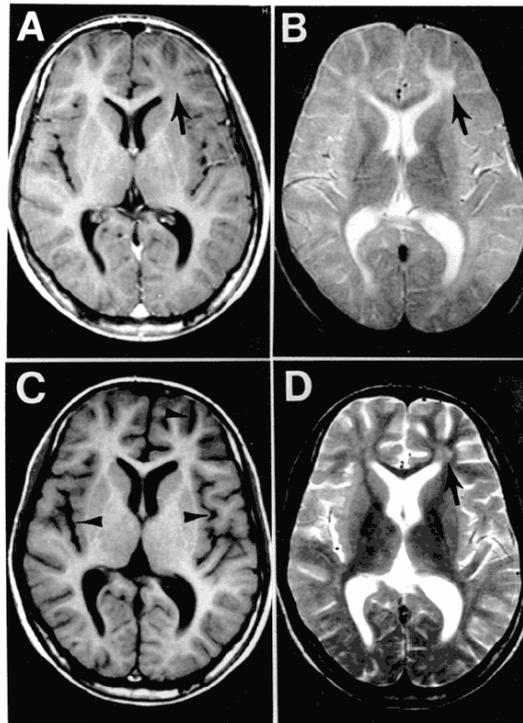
Brain MRI showing T_1 and T_2 weighted scans. Images A and C are T_1 weighted images; B and D are T_2 weighted images [http://physiology-physics.blogspot.co.uk/2010/07/relaxation-in-nuclear-microcosm.html, accessed on 15/04/2013]. Fluid appears dark on T_1 -weighted images, but bright on T_2 -weighted.
